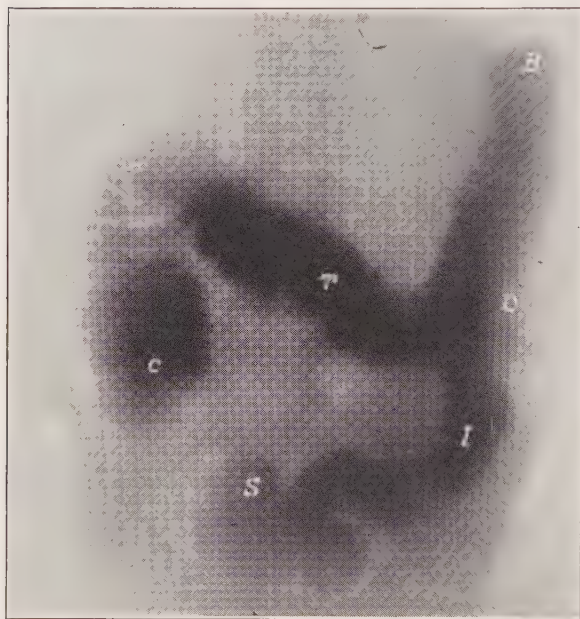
ROENTGENOGRAM OF NORMAL COLON.
